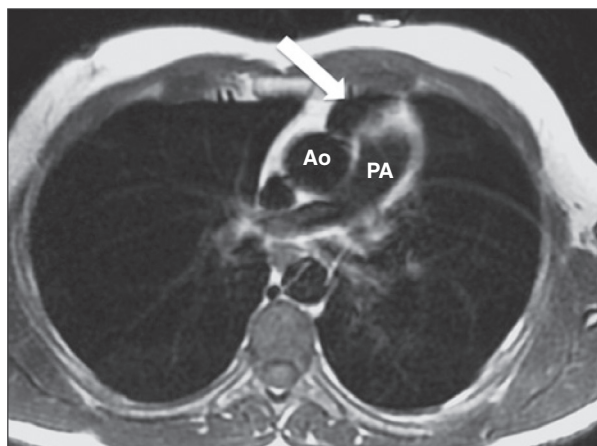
Chest magnetic resonance imaging showing the interposition of lung tissue between the aorta and pulmonary artery (arrow). Ao, aorta; PA, pulmonary artery.
